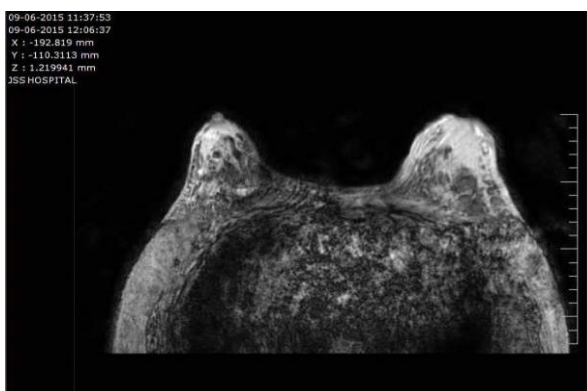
MRI of the abdomen and left breast
